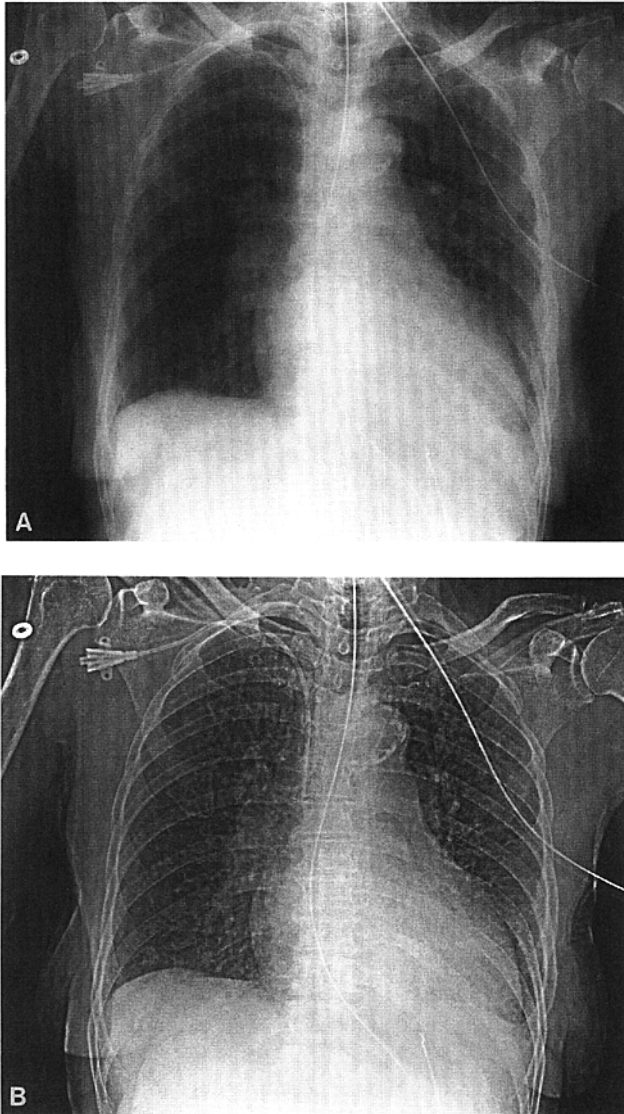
(A) Digitized image without image manipulation appears similar to a conventional chest radiograph. (B) The same image reconstructed with an edge enhancing algorithm shows the lines and tubes to better effect but produces distortion of the appearances of the lung parenchyma.
